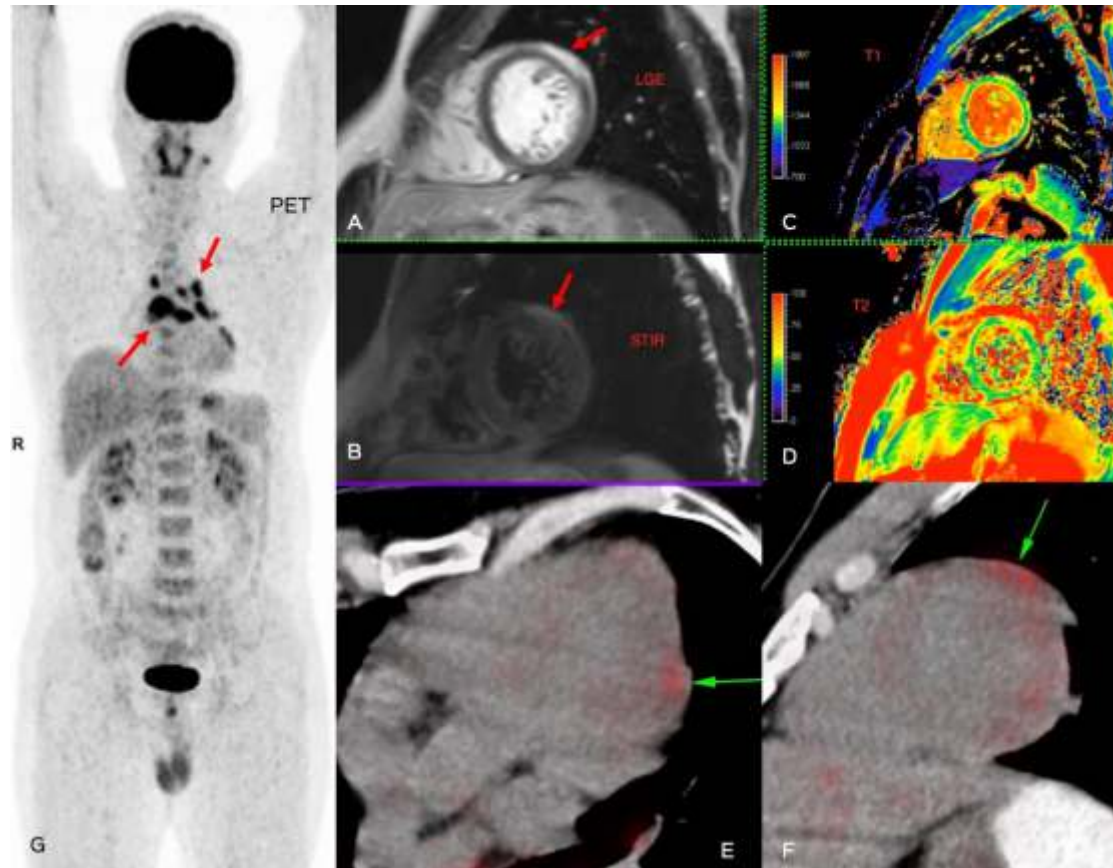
(A-G): 36-years old with monomorphic ventricular tachycardia. The short axis LGE image (A) shows abnormal mid-myocardial and epicardial enhancement in the basal anterolateral segment (arrow) with edema (arrow) on the STIR (B) image and raised T1 and T2 values (C,D). This is suggestive of a granulomatous cardiomyopathy (there were also lymph nodes on the axial images). The cardiac PET/CT (4-chamber – E and short axis – F) shows uptake (arrows) corresponding to the MRI lesions, suggesting active inflammation. The whole body PET (G) shows the typical “panda” distribution of the mediastinal and hilar nodes. All these findings are highly suggestive of sarcoidosis.
